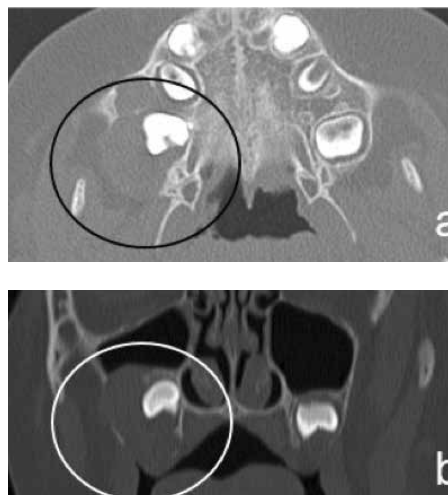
Preoperative axial (A) and coronal (B) CT-slices: the very large lesion also expands in the pterygoid-maxillary fossa (black and white circles)
